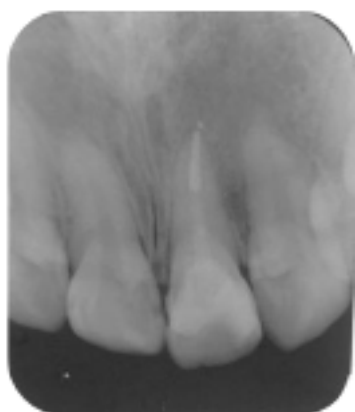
Three Months Recall Periapical Radiograph
